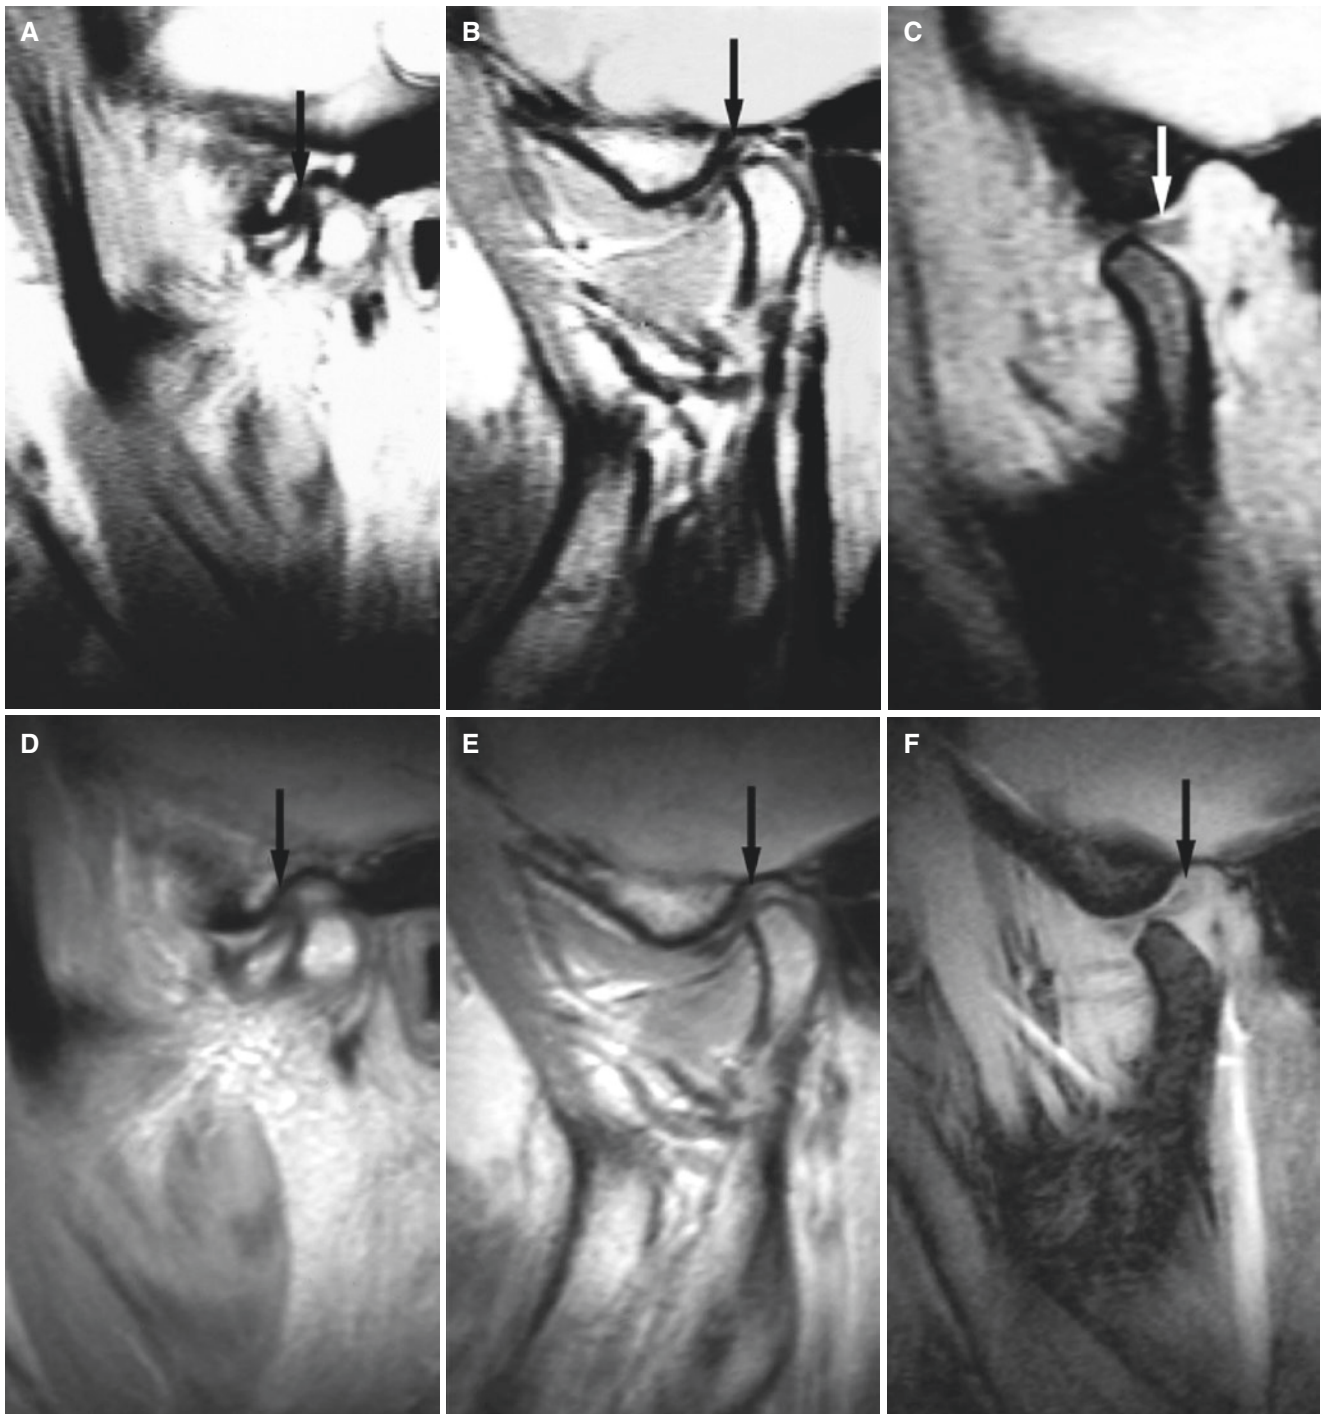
Partial anterior disc displacement at baseline (A, B, C) and at 8-year follow-up (D, E, F), normal bone; identical joint status (except function) at both examinations. (A, D) Oblique sagittal MRI shows displaced disc (*arrow*) in lateral sections. (B, E) Oblique sagittal MRI
